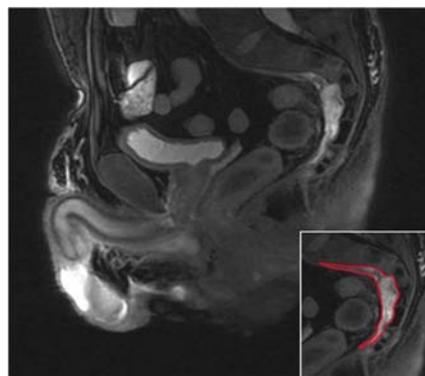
MRI image (T2 haste after gadolinium based contrast) : Mesorectal cyst (patient B).
